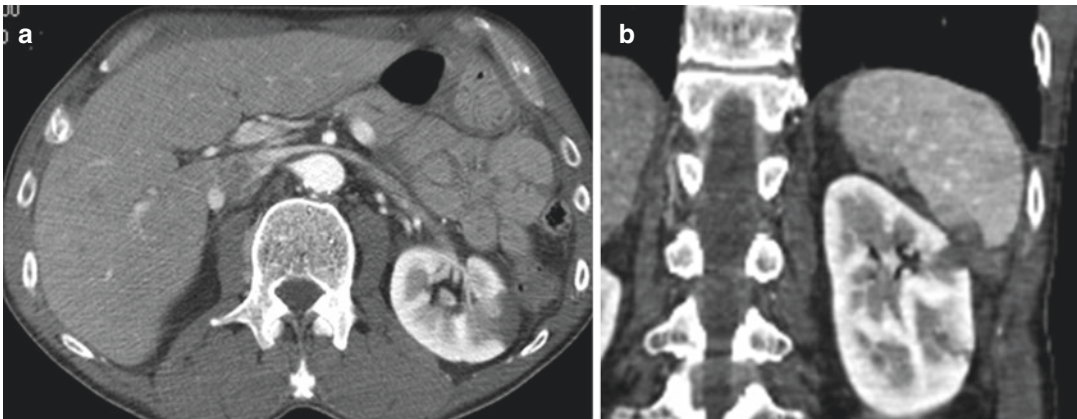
CT confirms CEUS findings. (a, b) Axial and coronal enhanced CT images confirm well the laceration of the upper pole of the kidney emerging to the renal surface. (c, d) Axial and sagittal enhanced CT images define
